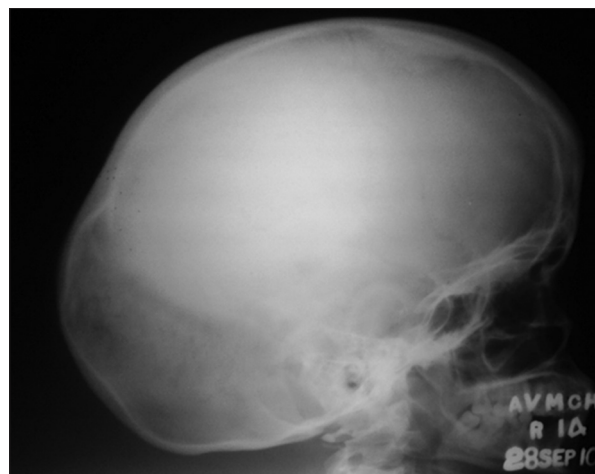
X-ray skull showing macrocephaly
